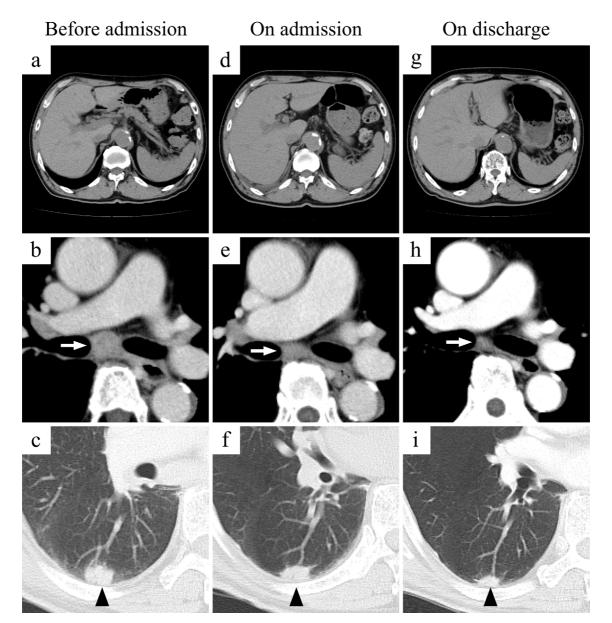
Changes in CT findings. The upper panels show the liver and spleen: (a) No abnormal liver or spleen findings were seen before admission. (d) Hepatosplenomegaly was detected on admission. (g) The liver and spleen sizes normalized before discharge. The middle panels show the inferior tracheobronchial lymph nodes (white arrows): (b) An enlarged lymph node was confirmed before admission. (e) The lymph node had appeared smaller on admission. (h) The lymph node had nearly normalized in size before discharge. The lower panels show the lung tumor in the right lower lobe (black arrow heads): (c) A lung nodule was seen before admission. (f) The lung nodule appeared smaller on admission. (i) The nodule had significantly decreased in diameter before discharge.
